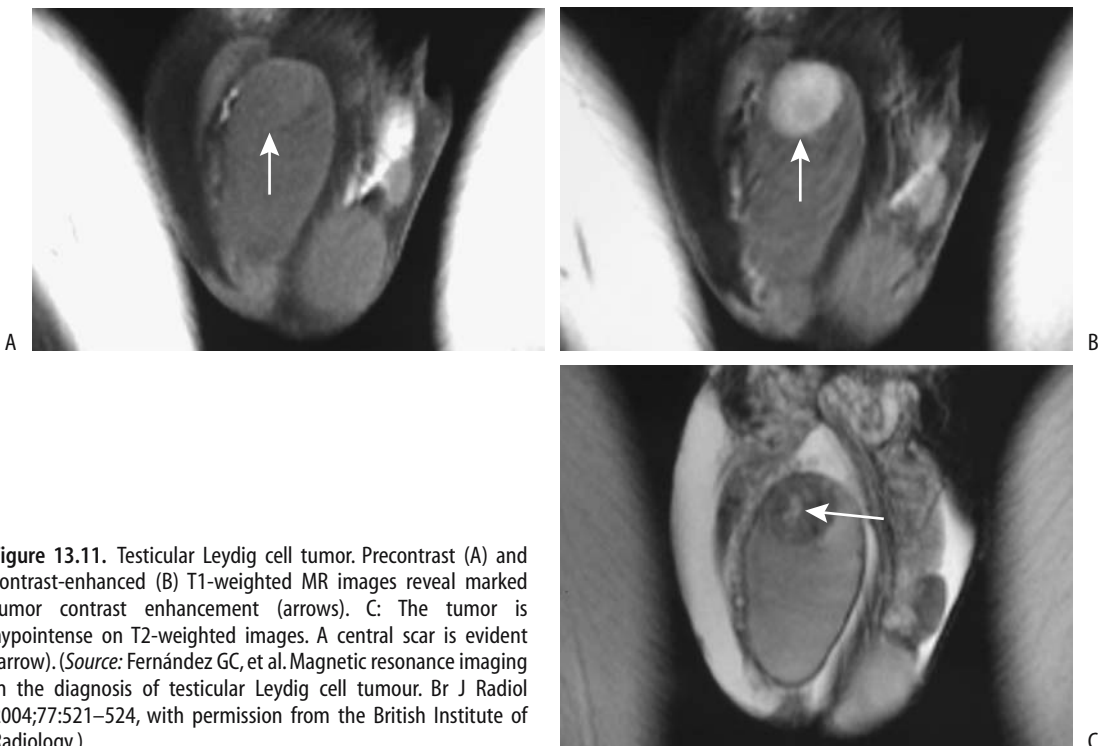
Testicular Leydig cell tumor. Precontrast (A) and contrast-enhanced (B) T1-weighted MR images reveal marked tumor contrast enhancement (arrows). C: The tumor is hypointense on T2-weighted images. A central scar is evident (arrow). (Source: Fernández GC, et al. Magnetic resonance imaging in the diagnosis of testicular Leydig cell tumour. *Br J Radiol* 2004;77:521–524, with permission from the British Institute of Radiology.)
